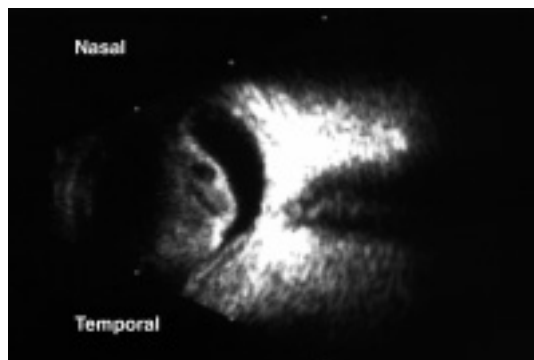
Ultrasound right eye, horizontal section, showing dense vitreous haemorrhage and choroidal elevation involving macula.
